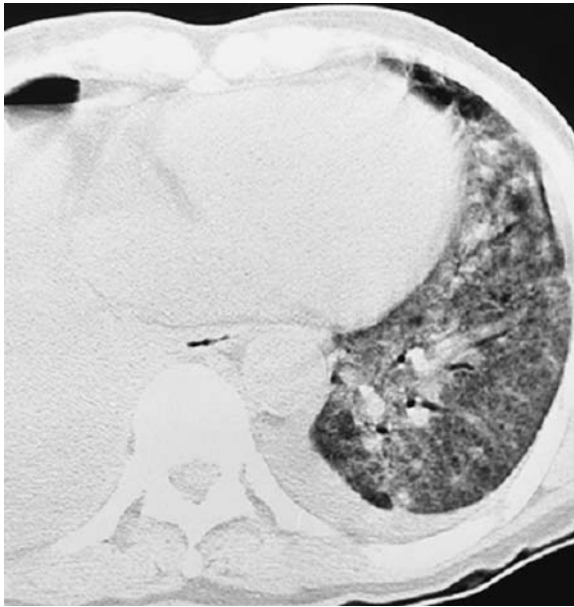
Transverse CT section shows ground glass opacities and reticulations in an ARDS-affected lung
